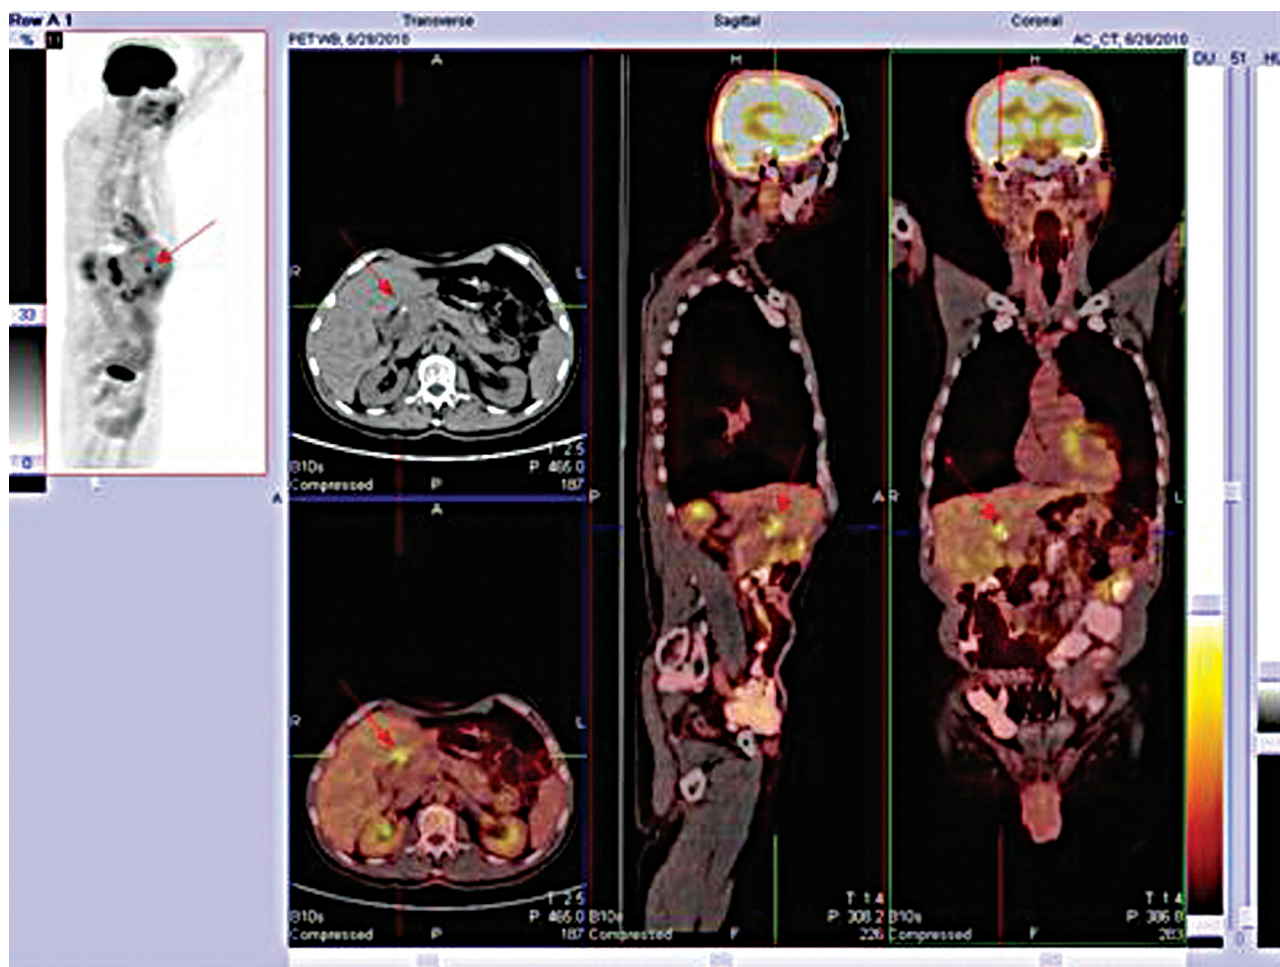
FDG PET/CT shows intense heterogeneous uptake foci in the gallbladder, which was primarily compatible with inflammation (SUVmax: 2.4).
